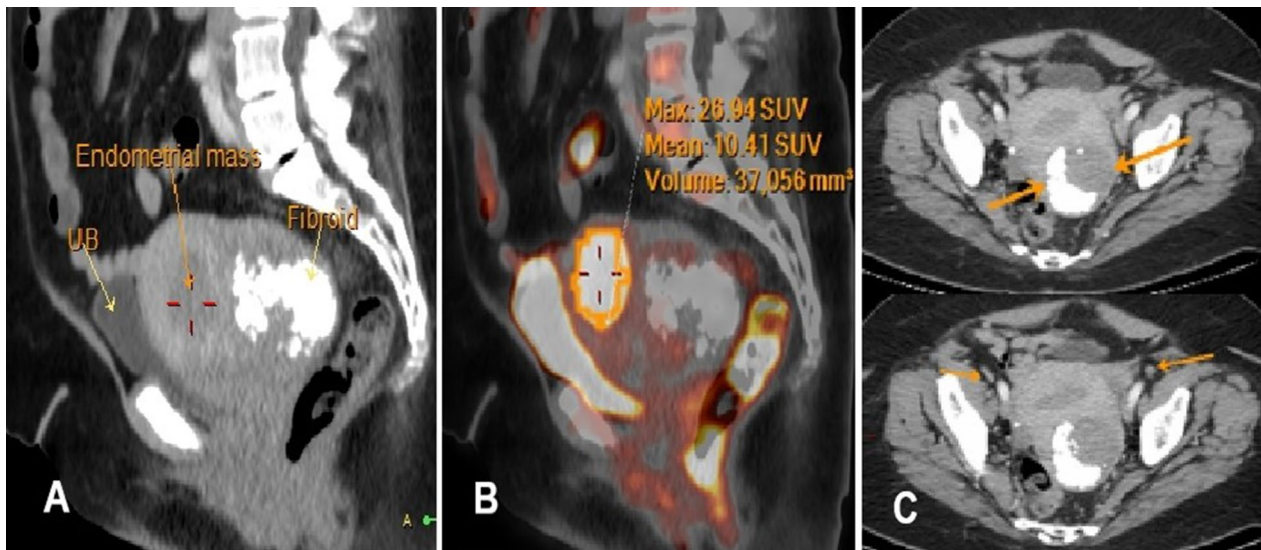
The uterus is enlarged, showing endometrial intensely avid heterogeneous soft tissue lesion, measuring $\pm 40 \times 34 \times 19$ mm [Image A]. The myometrium shows few fibroids, and the largest one [measuring $\pm 7 \times 6$ cm] is seen at the posterior wall, accommodating internal confluent dystrophic calcifications. The endometrial lesion achieves 26.9 SUV_{max} , 10.4 SUV_{mean} and $MTV = 37,056$ mm³ at the corresponding PET images [image B]. Bilateral few small non-avid external iliac lymph nodes [arrows, image C, superior image], measuring 11 \times 4 mm and 10 \times 9 mm on the right and left side, respectively. No hypermetabolic pelviabdominal lymphadenopathy detected
